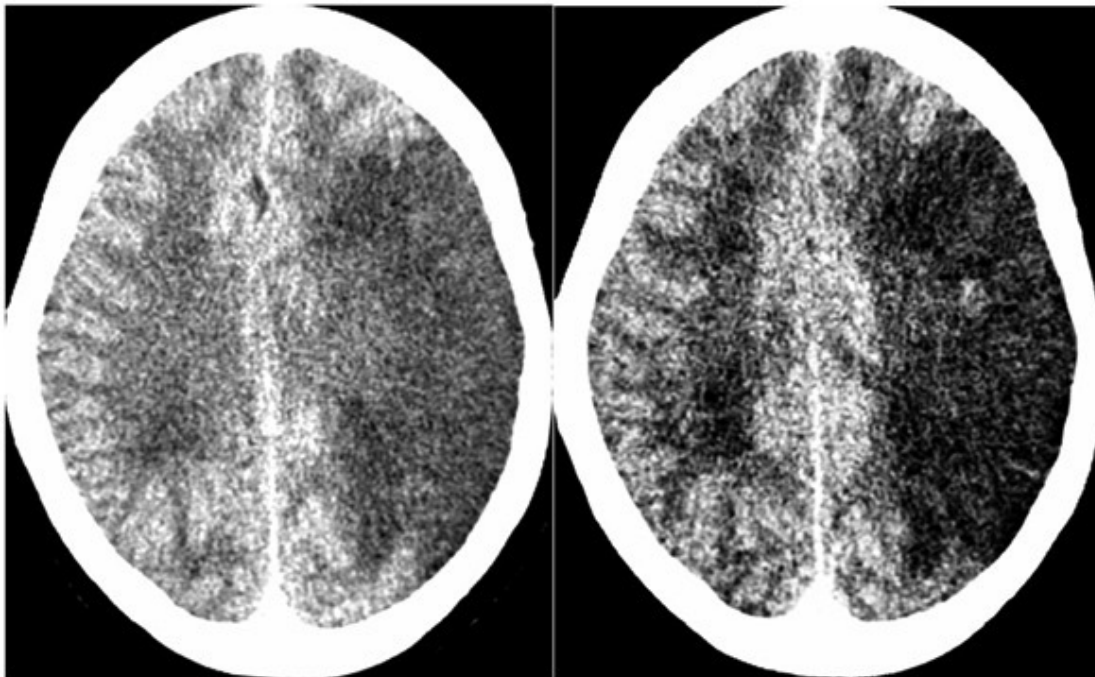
Unenhanced CT scan, both same images at same axial level. Note the difference in density is evident between films on either side (hypodensity on left hemisphere on right film is better appreciated). This is done by changing in window setting to better evaluate area of hypodensity.
